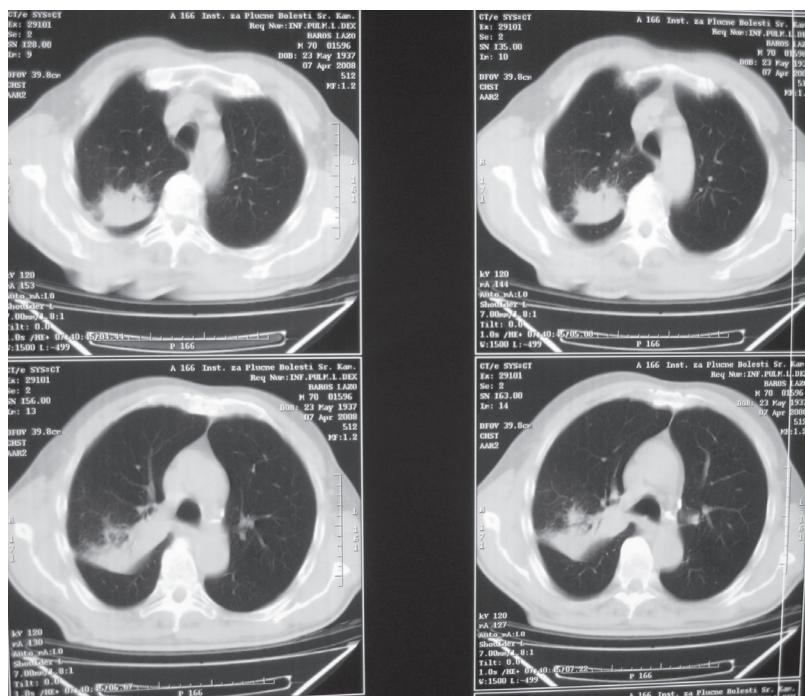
Computed tomography scan findings of the chest did not reveal enlarged mediastinal lymph nodes
